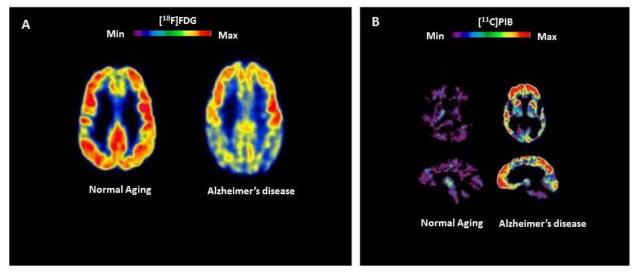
A) FDG PET patterns characteristic of metabolic activity in cognitively normal individuals and patients with LOAD. Red: high FDG uptake, Blue: low FDG uptake. Compared to persons aging normally, persons with LOAD show decreased bilateral glucose metabolism particularly in the temporal and parietal regions. B) PIB PET images characteristic of elderly individuals without cognitive impairment and patients with LOAD. Red: high PiB retention, Purple: low PiB retention. The image of the LOAD case shows red and yellow areas indicating high concentrations of PiB in the brain thereby suggesting high amounts of amyloid deposits.
